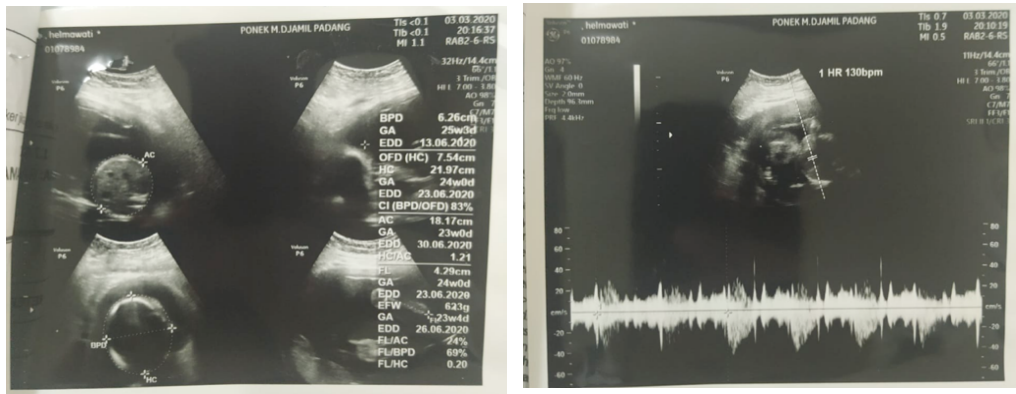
Ultrasound Examination
